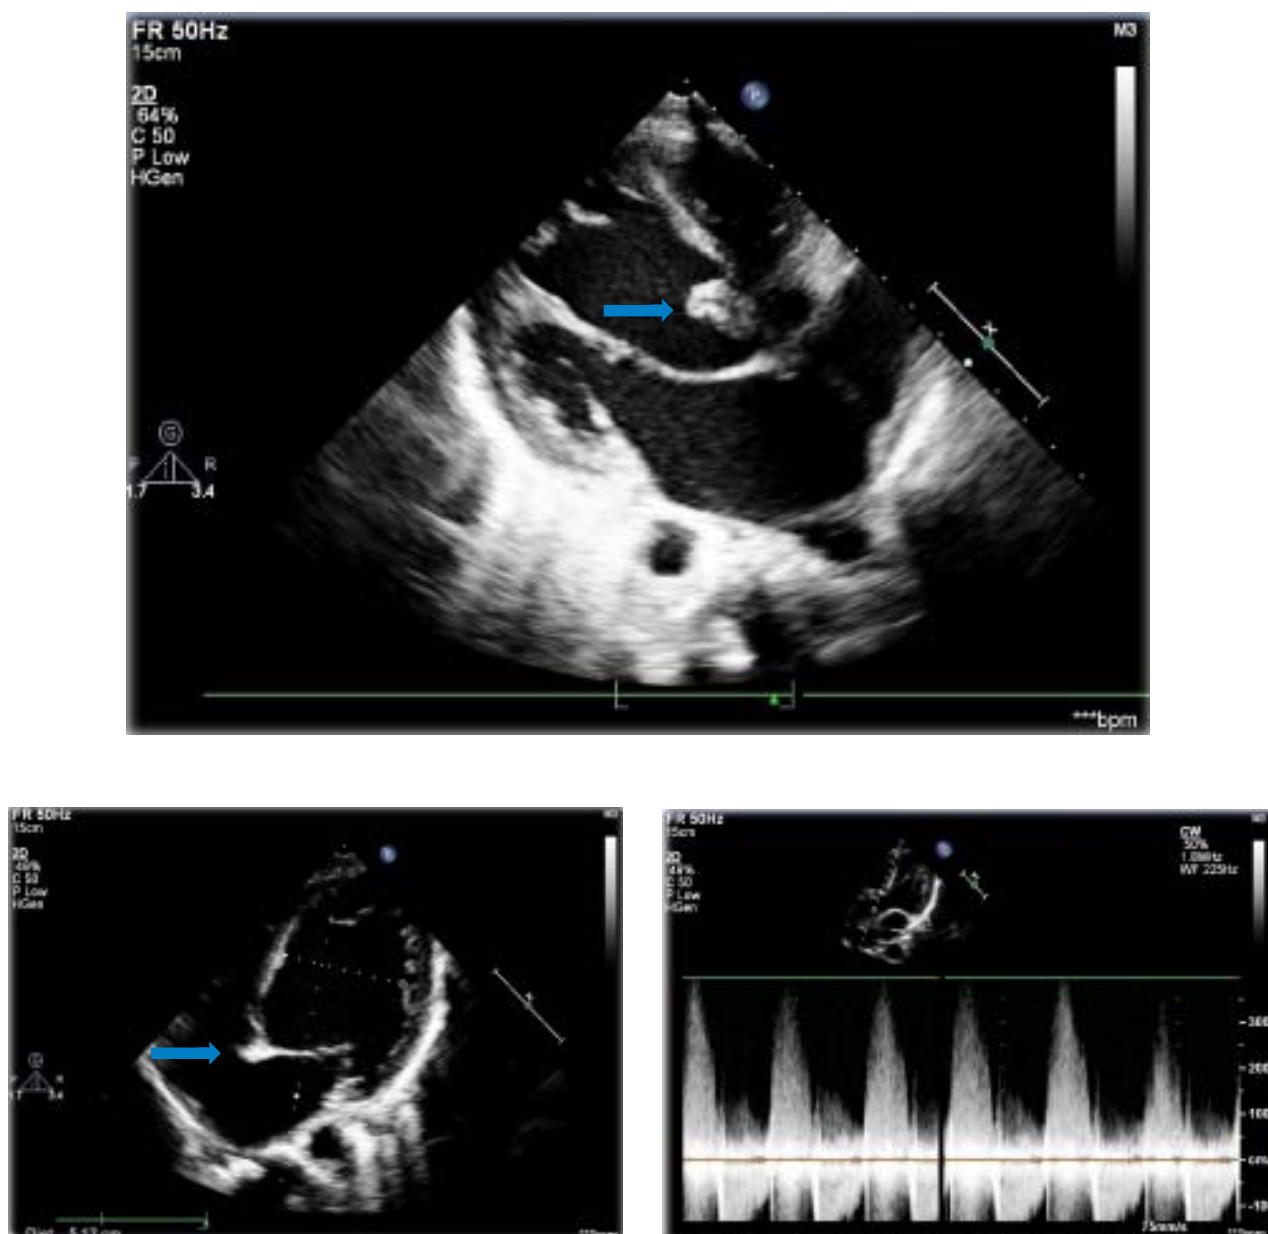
Transthoracic echocardiography (blue arrow heads denote the vegetation of aortic valve).
